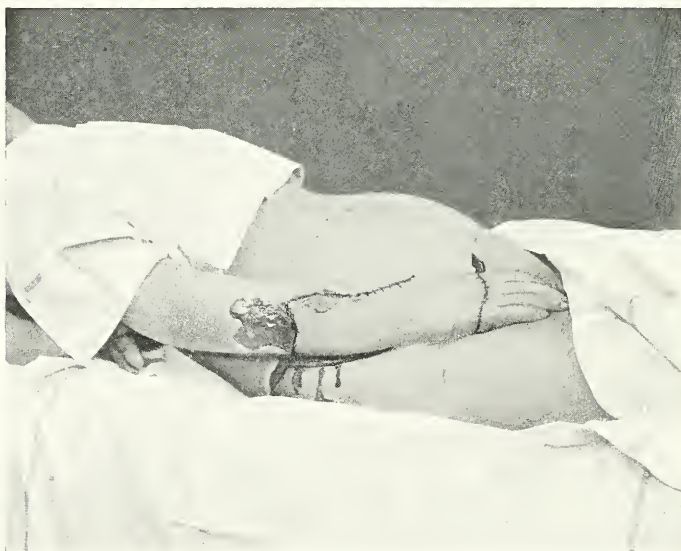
REPARATION OF CUTANEOUS LOSS OF SUBSTANCE INVOLVING THE WHOLE DORSUM OF HAND AND DORSAL AND EXTERNAL ASPECTS OF FOREARM.
